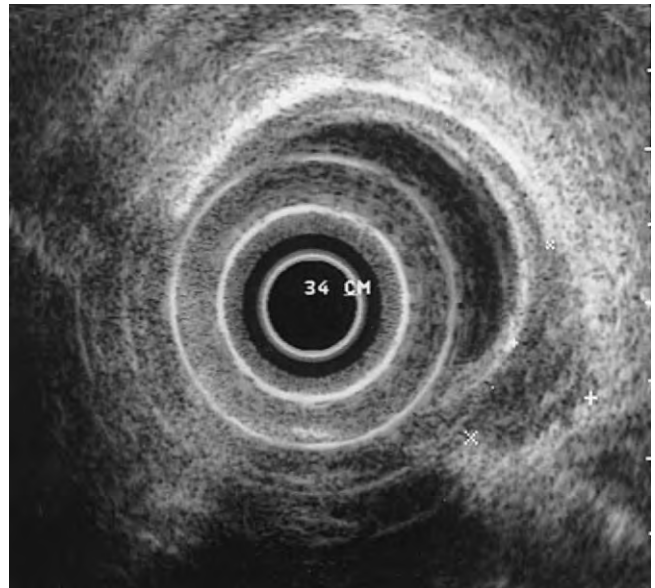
Endoscopic ultrasound of a leiomyoma demonstrating the size and location of the tumor. The tumor borders are marked by the three scan markers (*, x, +).
